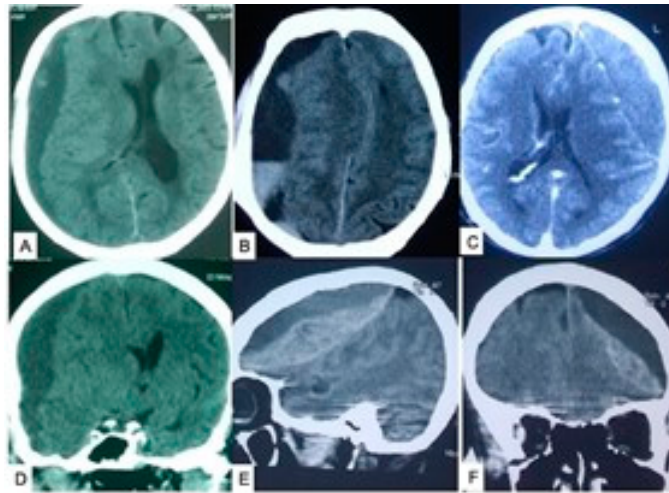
CT head shows fluid levels in chronic SDH (A–F). Source: Figure by authors.
